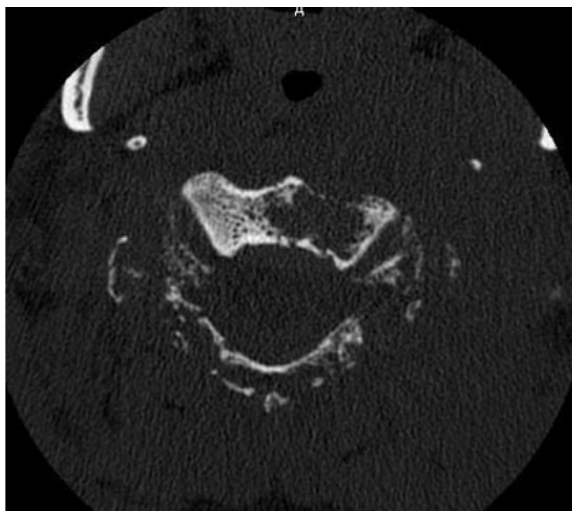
Preoperative axial CT image of cervical spine demonstrating osteolytic erosion of vertebral body by soft tissue mass.
